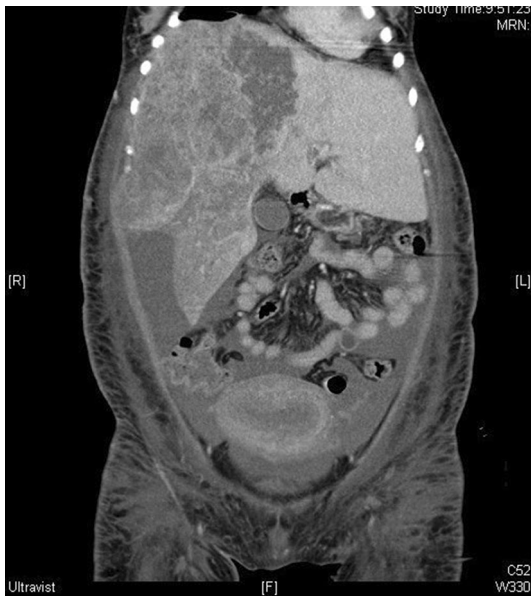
CT Scan C: large heterogeneous hypovascular mass with irregular edges that presents a peripheral enhancement
